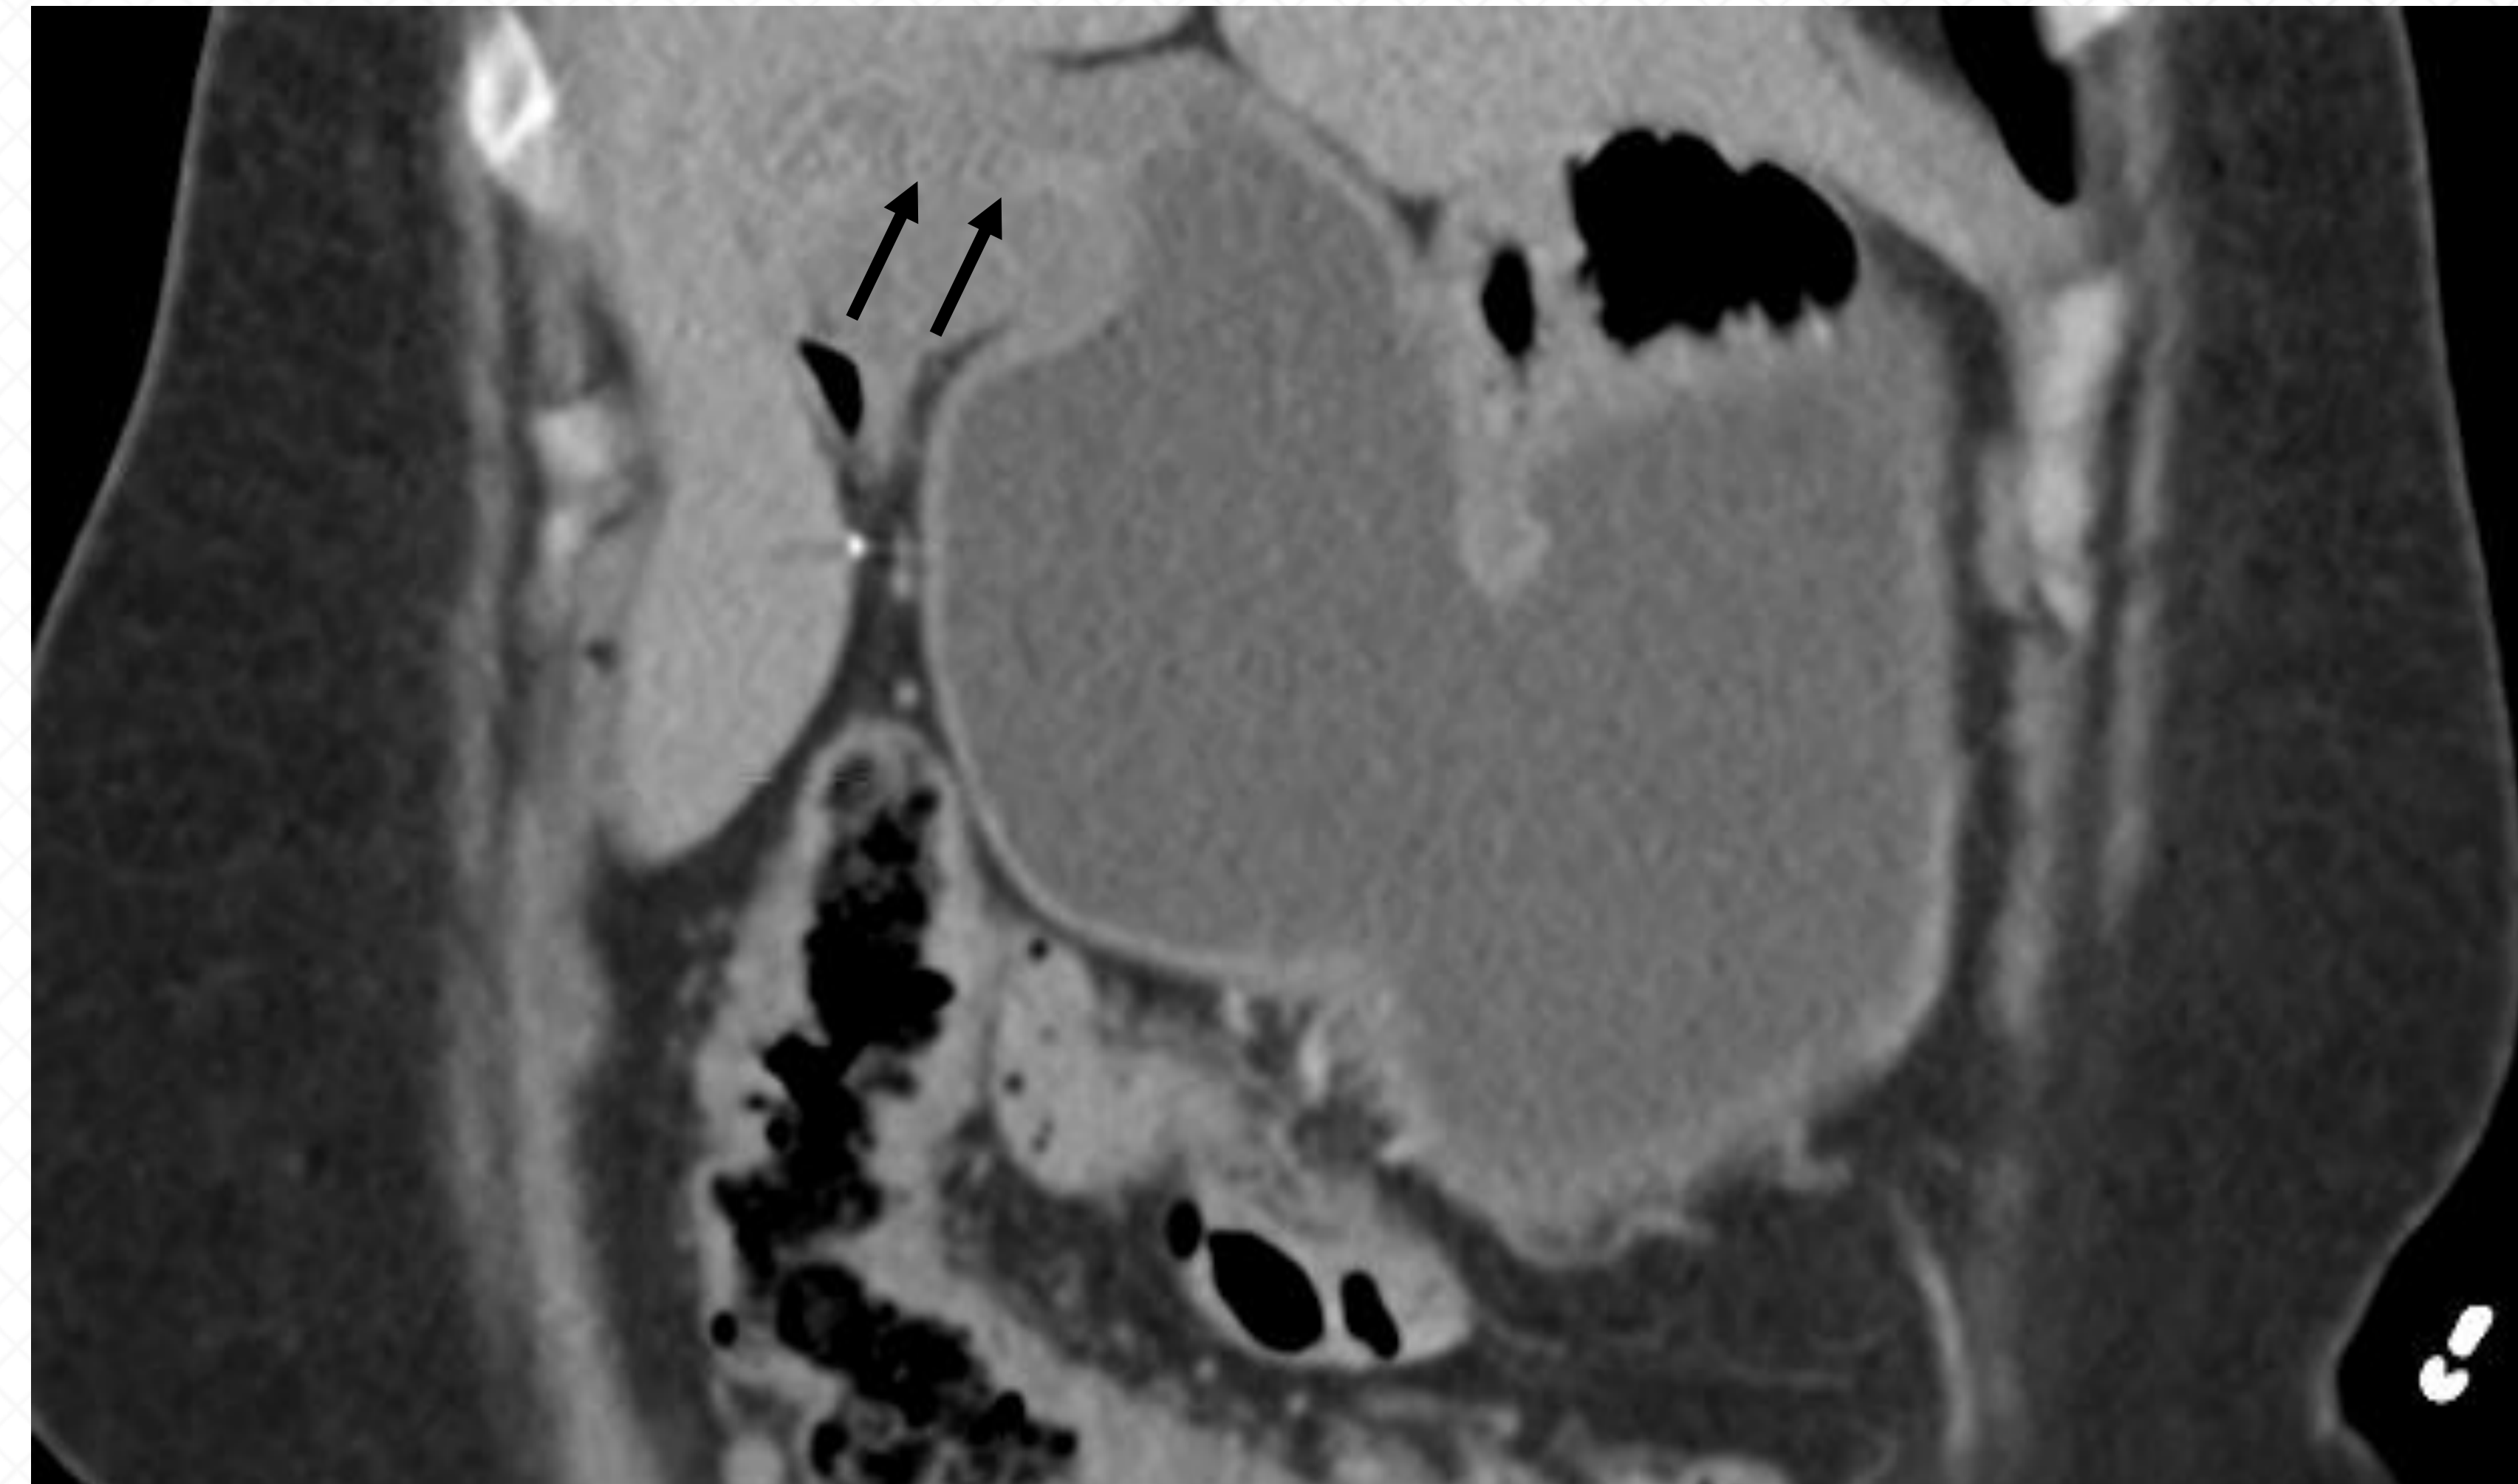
CT scan of the abdomen showing dilated bypassed stomach with thickened and narrow pyloric channel (Black arrows)
